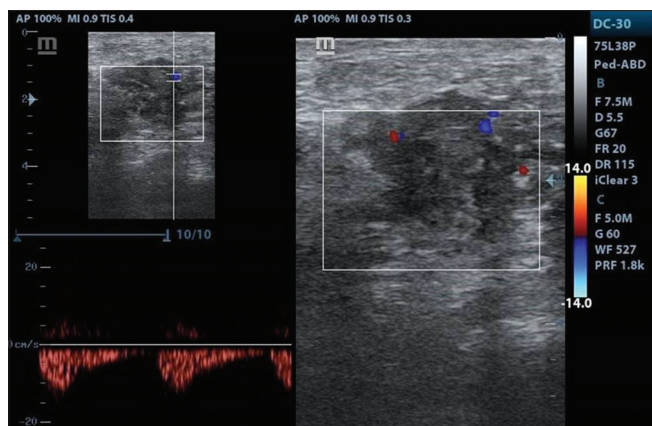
US image shows an ill-defined spiculated margin heterogenous hypoechoic breast lesion. Pulse-wave Doppler shows peripheral blood flow of malignant lesion. CNB revealed breast carcinoma
